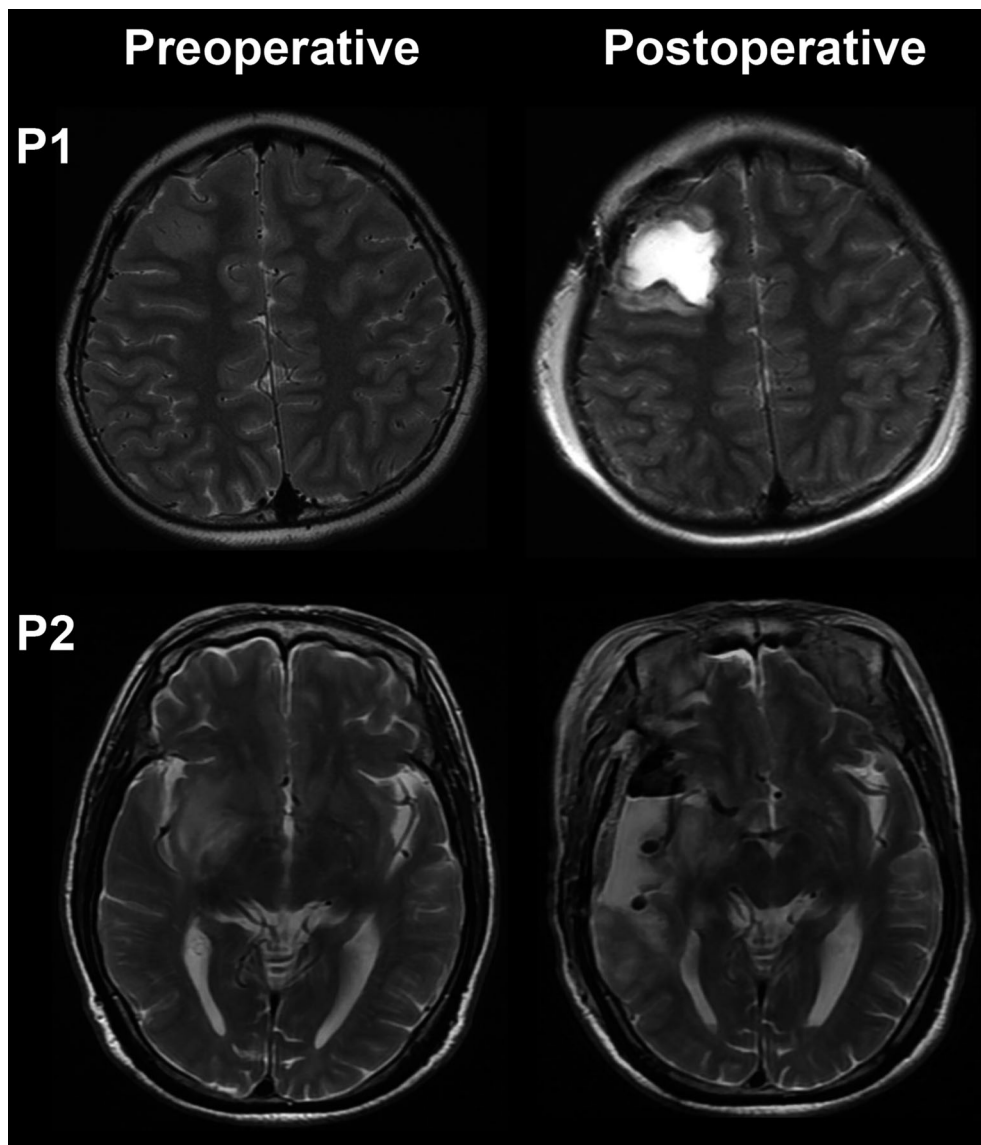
Preoperative and postoperative images of epilepsy patients with LGT. (P1) T2 preoperative MRI image (left) showing right frontal tumor of a 9-year-old boy with epilepsy. Postoperative MRI image (right) showing that the lesion was completely resected. The patient was seizure-free after a 3-year follow-up. (P2) T2 MRI image (left) of a 68-year-old male with a right temporal-insular tumor. The postoperative MRI image (right) showed residual tumor tissue in the right insular lobe, and the patient had recurrent seizures in the first year after surgery.
